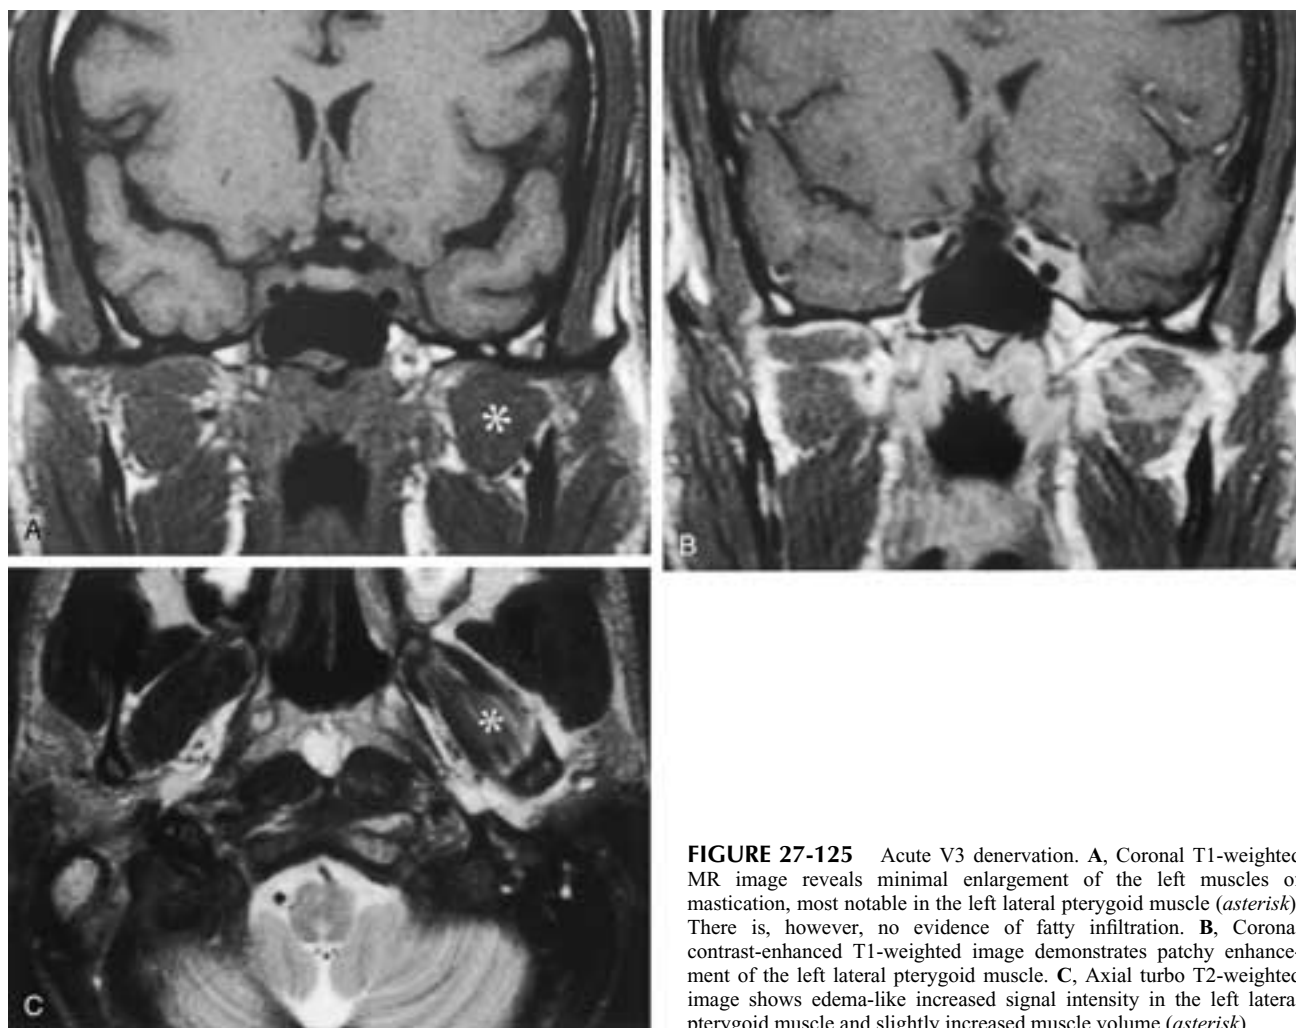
Acute V3 denervation. A, Coronal T1-weighted MR image reveals minimal enlargement of the left muscles of mastication, most notable in the left lateral pterygoid muscle (*asterisk*). There is, however, no evidence of fatty infiltration. B, Coronal contrast-enhanced T1-weighted image demonstrates patchy enhancement of the left lateral pterygoid muscle. C, Axial turbo T2-weighted image shows edema-like increased signal intensity in the left lateral pterygoid muscle and slightly increased muscle volume (*asterisk*).
